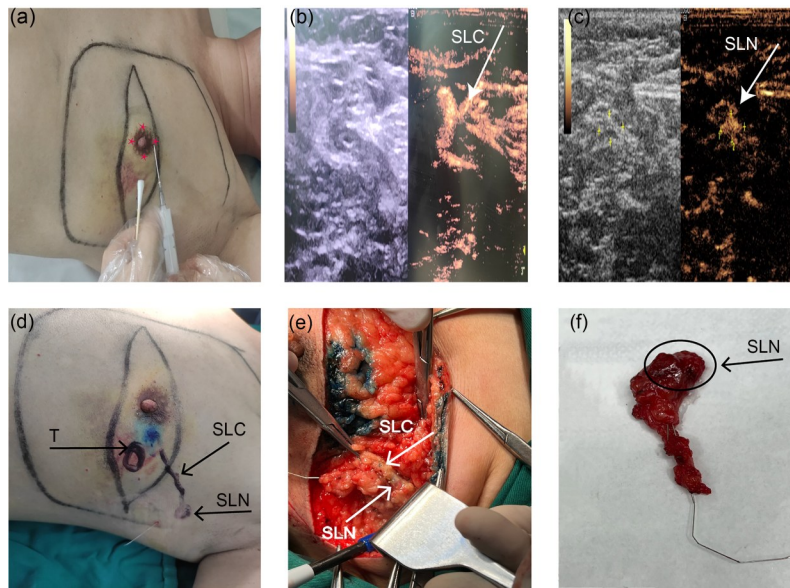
Trans-areolar subcutaneous injection of ultrasound contrast agents (UCAs) tracing sentinel lymph nodes (SLNs). (a) Subcutaneous injection of SonoVue at the 3, 6, 9, and 12 o'clock positions in the affected areola. (b) Enhanced image of sentinel lymphatic channel (SLC). (c) Enhanced images of SLN. (d) Skin surface markers of tumor (T), SLC, and SLN. (e) Intraoperative methylene blue (MB) development of SLC and SLN. (f) The SLN of contrast-enhanced ultrasound (CEUS) wire positioning is consistent with the MB positioning.
